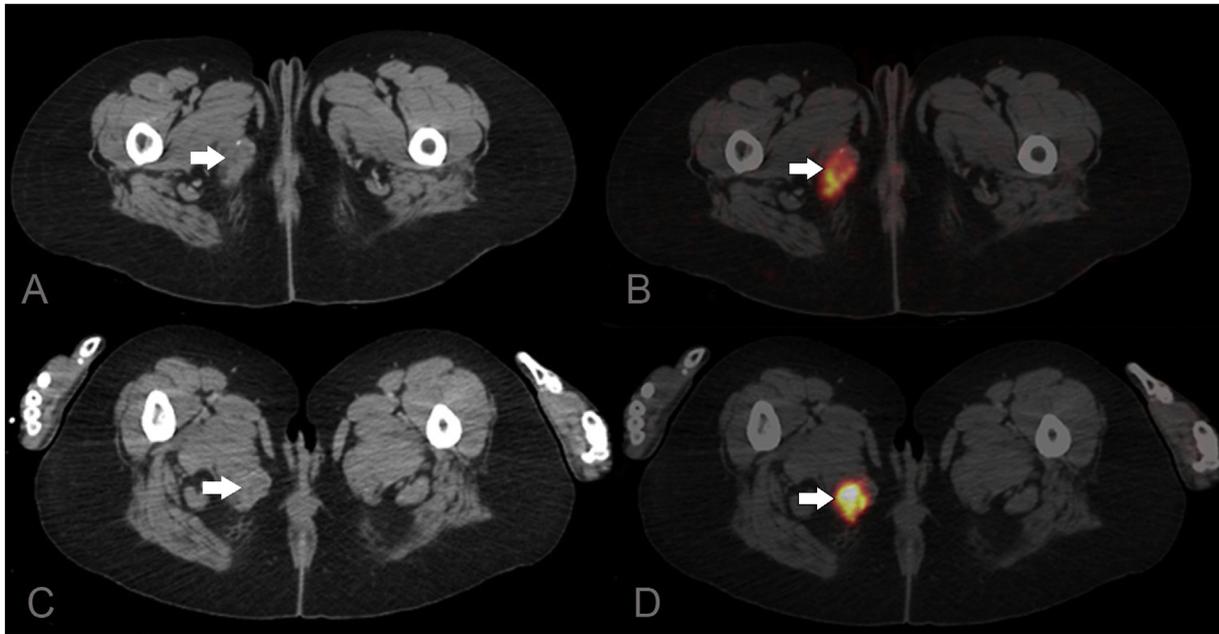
40-Year-old female with bone pains and proximal myopathy. (A) Transaxial CT (B) fused FDG PET/CT (C) transaxial CT and (D) fused Ga-68 DOTATATE PET/CT localizing radiotracer uptake within a soft tissue lesion in the right posterior thigh. The lesion demonstrates standardized uptake values of SUV 8.3 and SUV 18.2 on FDG and Ga-68 DOTATATE, respectively. Pathology was consistent with phosphaturic mesenchymal tumor.
